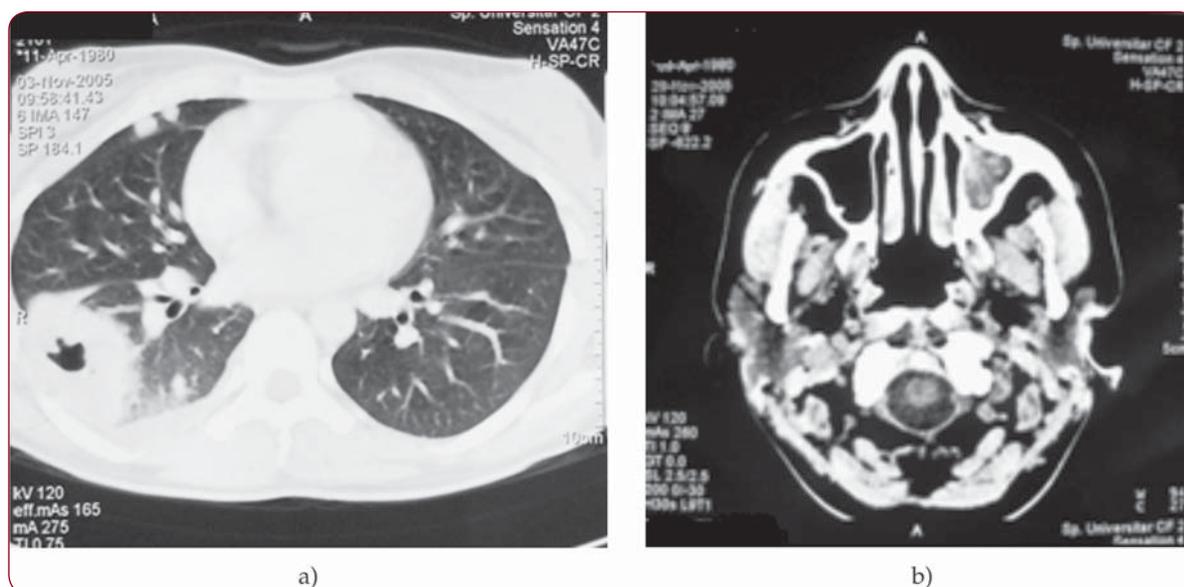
CT scans of the lung and sinuses at a patient with Wegener granulomatosis diagnosed in our clinic showing a) nodular lung lesion with necrosis; b) left maxillary sinusitis
